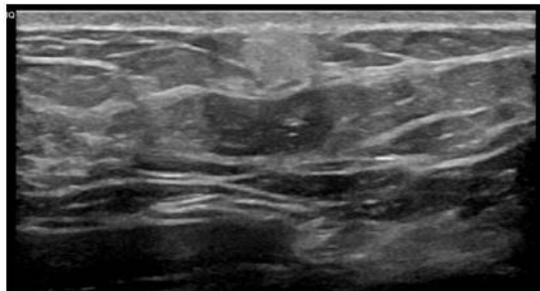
Ultrasound of the left breast demonstrates an 8 x 6 x 8 mm mass.
